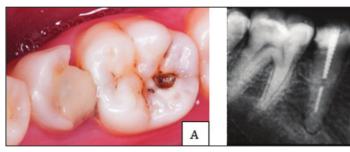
(A) Initial intraoral condition of tooth no. 45. (B) Intraoral periapical radiograph showing previously treated root canal treatment and metal nost
